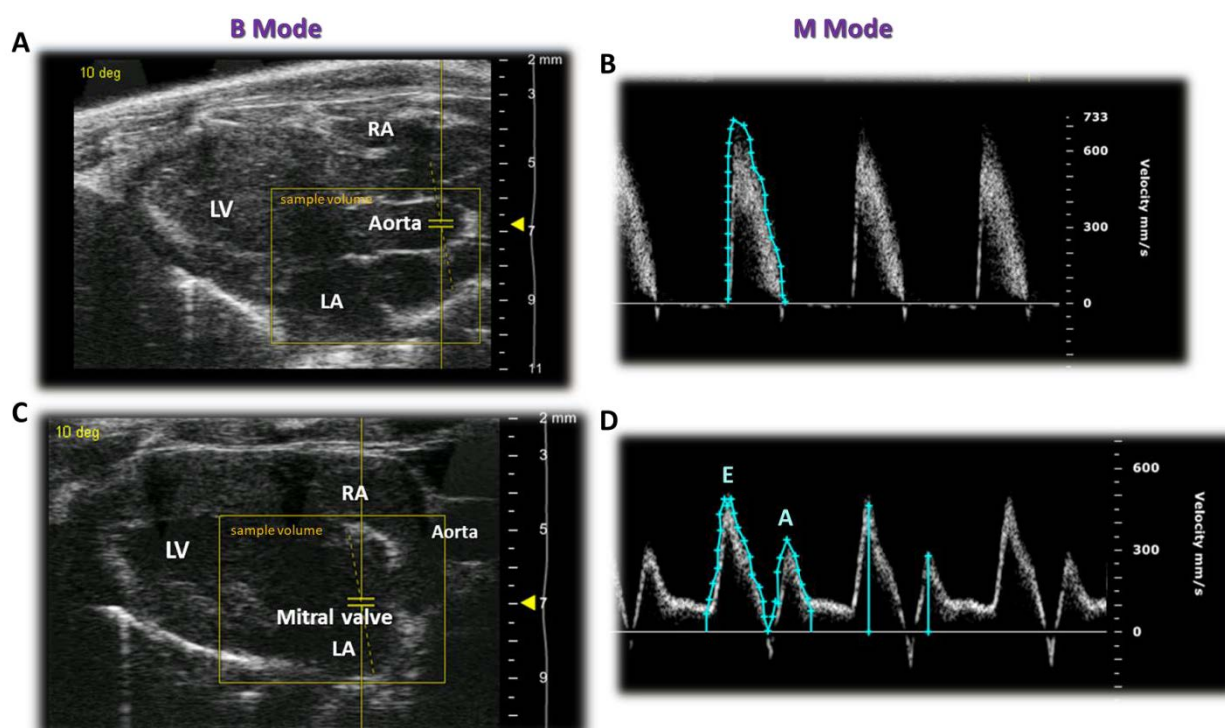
Echocardiography Doppler flow of aortic and mitral valve flow
